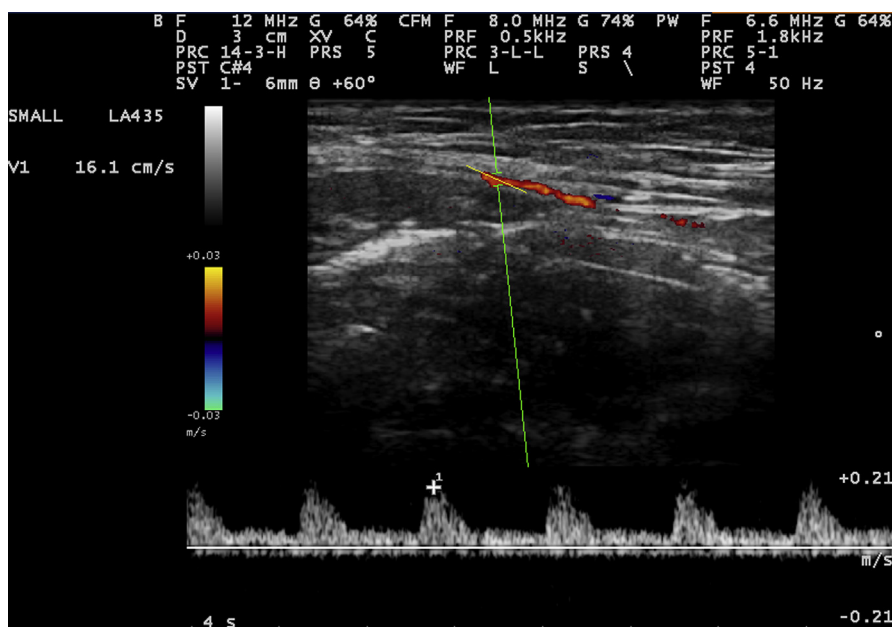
The superficial circumflex iliac artery was tracked by Color Doppler sonography and the velocity of the bloodstream was calculated.
